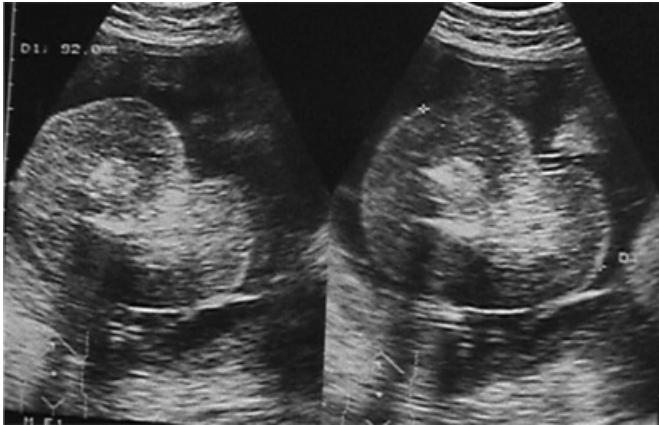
Sonography of the acardia fetus that shows deformed lower limbs with no heart and upper half of body.
